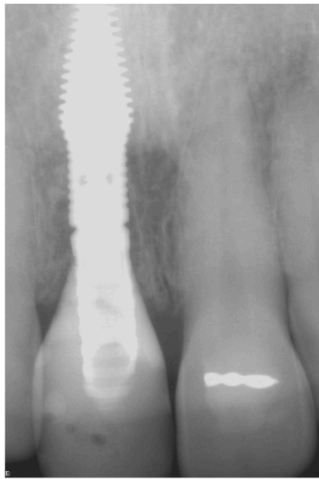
Post-operative radiograph confirming complete seating of the provisional restoration and the dual-zone bone graft is visible mesially and distally.
